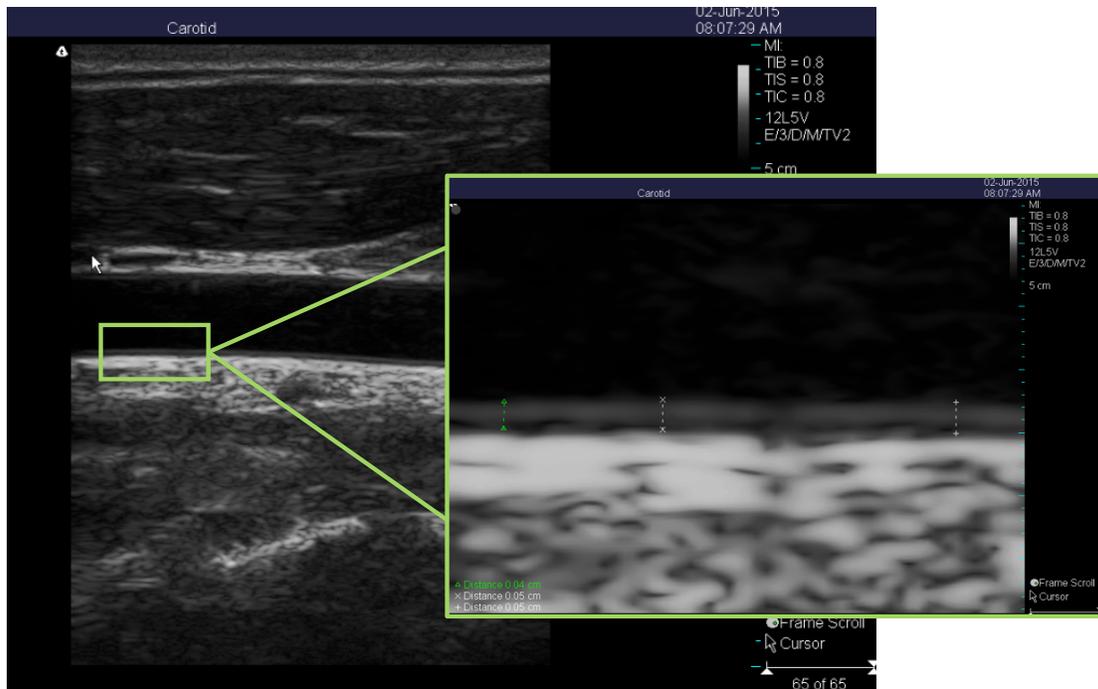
B-mode ultrasound image focusing on the distal wall of the common carotid artery, imaged from the posterior angle. A region of interest was magnified and calipers within the Terason software were used to measure from the lumen-intima interface to the media-adventitia interface in triplicate.
